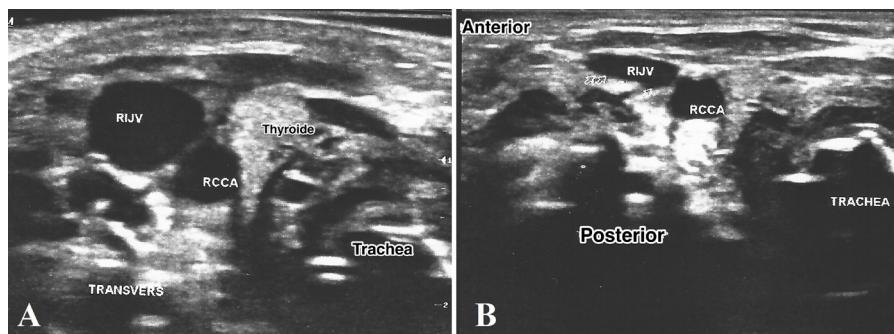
Ultrasonographic image of the jugular vein and common carotid artery on the transverse plane with and without compression. A: without compression. Internal jugular vein lies on the lateral side of the common carotid artery. B: with compression. Notice how the vein response to the compression.
